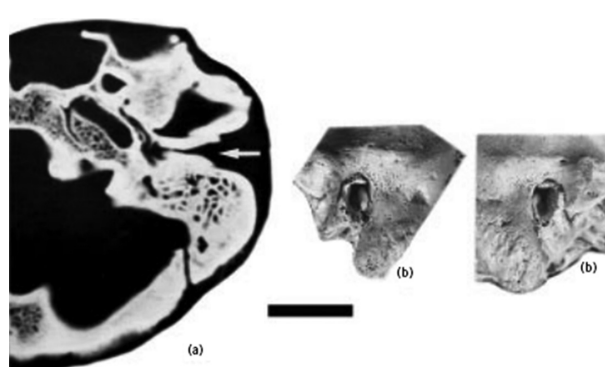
Computed tomography of cranial remains from the Sima de los Huesos Middle Pleistocene site, Sierra de Atapuerca, Spain, showing stenosis of left auditory canal (a), left auditory meatus of the cranium (b) and right auditory meatus of the cranium (c). Scale bar = 1cm. Reprinted with permission from Elsevier.⁴²
